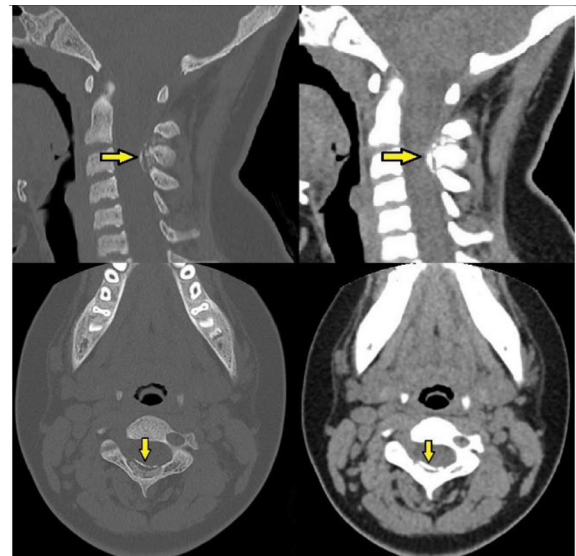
Sagittal and axial noncontrast computed tomography of the cervical spine in bone and soft tissue windows demonstrates fluffy epidural ossification within posterior spinal canal at C2-C4 level with scalloping of the adjacent laminae.
